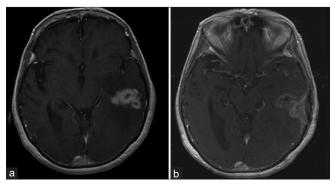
(a) Initial contrast-enhanced T1-weighted axial MRI scan demonstrating a heterogeneously enhancing mass in the left temporal lobe with surrounding vasogenic edema. (b) Immediate postoperative contrast enhanced T1-weighted axial MRI.
